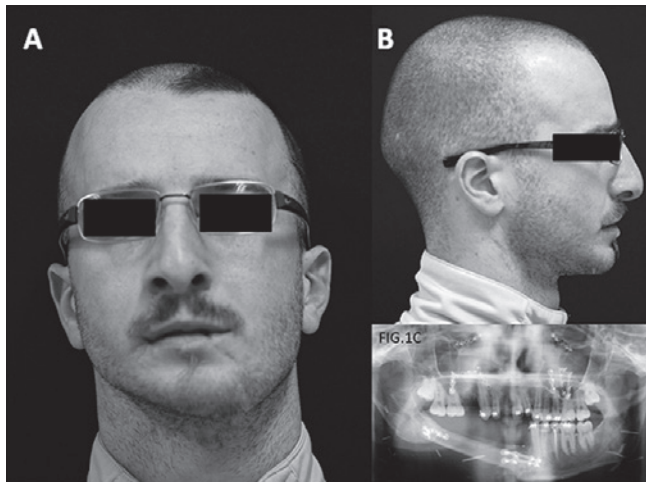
Aesthetic outcome after fibula free flap reconstruction: frontal view (A), lateral view (B) and orthopantomography (C).
